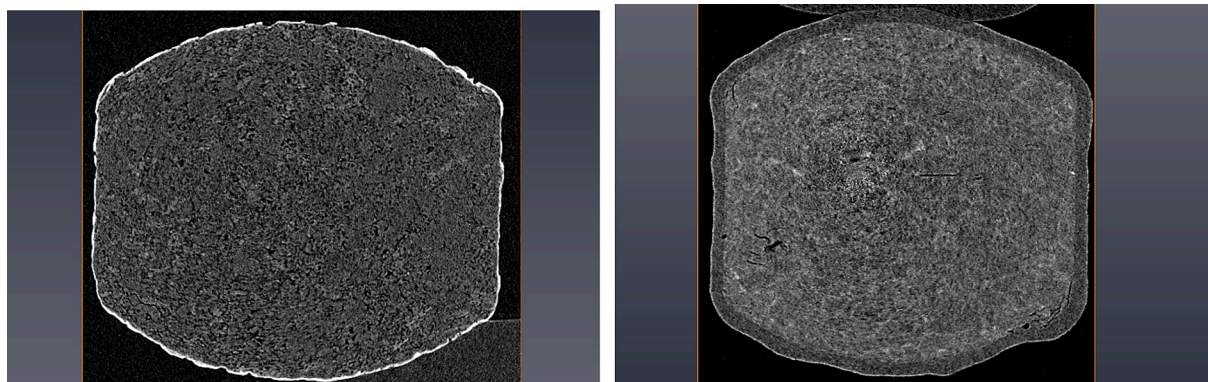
μ CT virtual slit images of levetiracetam 2 mm mini-tablet (Levetiracetam Desitin) with taste-masking coating (left) and sodium valproate mini-tablet (Orfiril® long by Desitin) with tablet cores of 1.7 mm and SR coating with a thickness of about 150 μ m.
